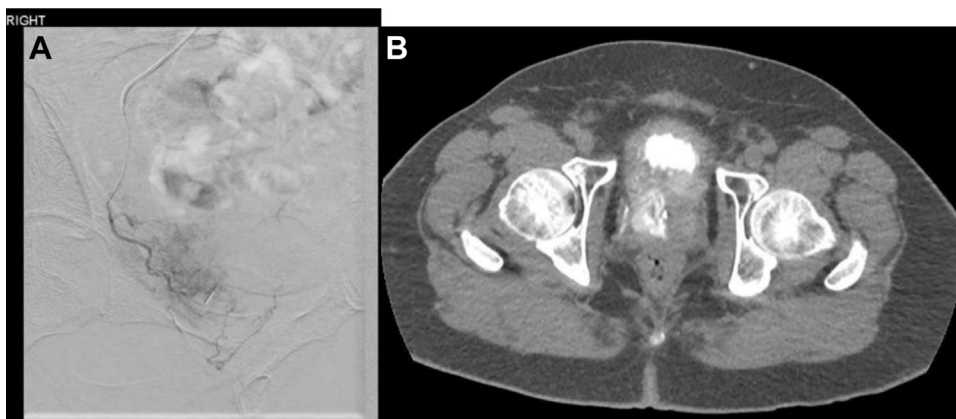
Prostatic artery embolization. (A) Digital subtraction angiogram image shows hypertrophied right prostatic artery (RPA) arising from the anterior division internal iliac artery via common vesicoprostatic trunk. (B) Limited contrast enhanced computed tomography (CT) confirms RPA catheterization and no collateral flow.
